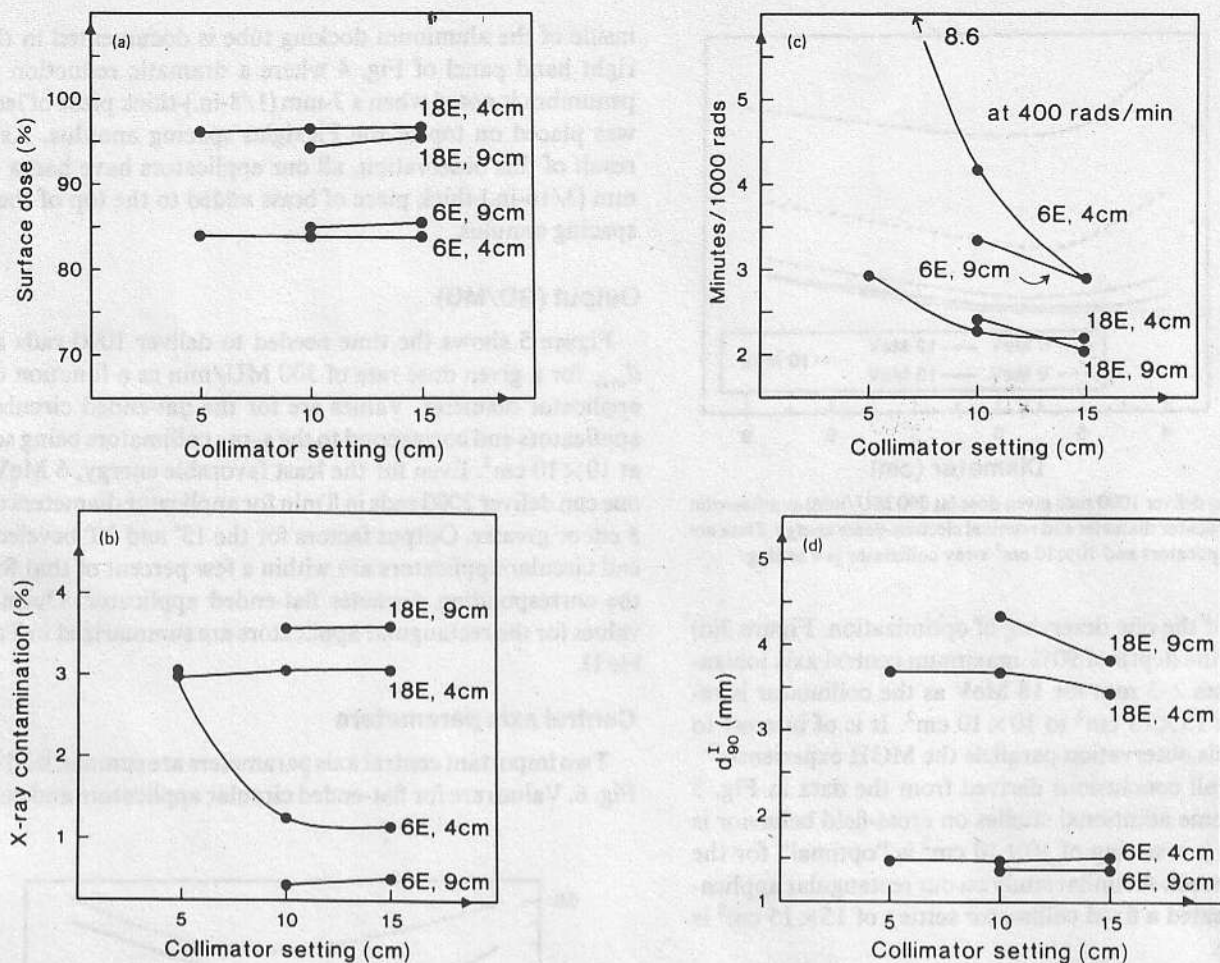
Variation of (a) surface dose and (b) x-ray contamination, (c) minutes to deliver 1000 rads given dose (at 400 MU/min) and (d) depth of 90% of central axis maximum ionization location as a function of x-ray collimator setting.
